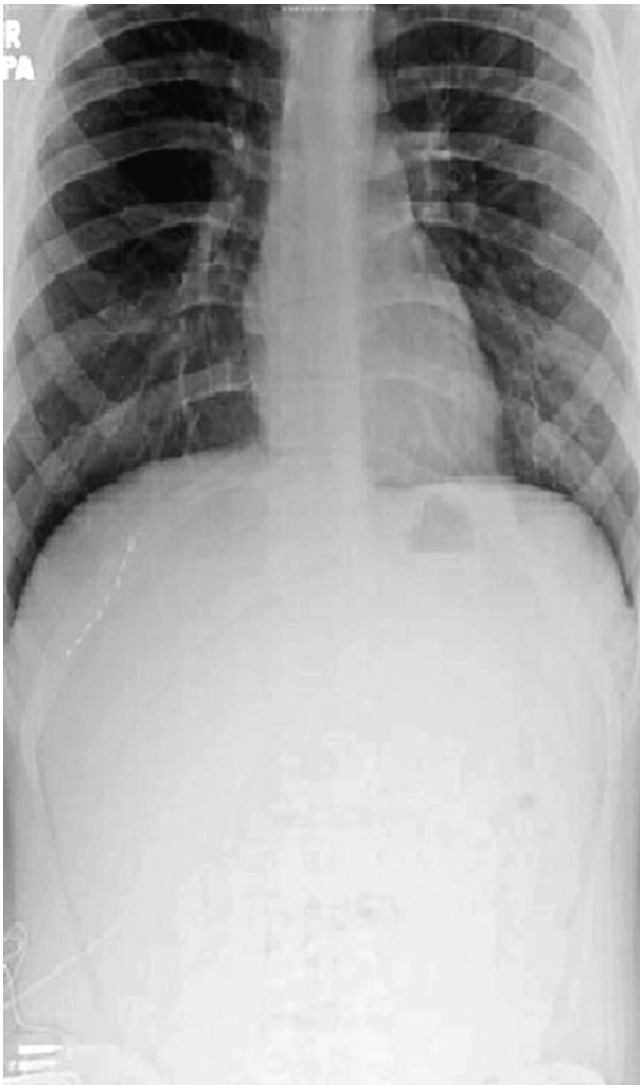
Radiograph of T11 intercostal nerve percutaneous PNS [30]
